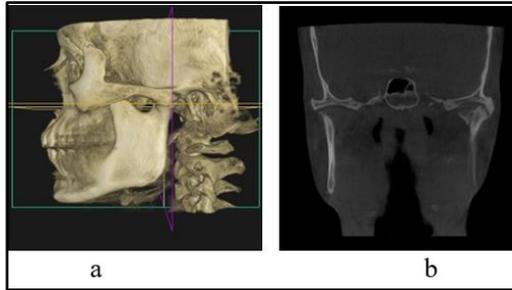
a: Pre CBCT radiograph b: Pre operative CBCT radiograph
